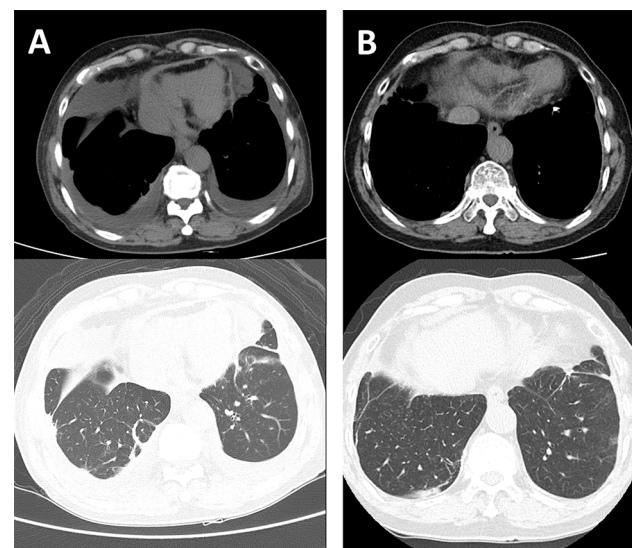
HRCT imaging. Chest computed tomography showed some calcified granuloma within the pleura in the left lower lobe, as well as bilateral pleural effusion with some linear consolidation and a small amount of pericardial effusion (A). Pleural effusion, pericardial effusion, and linear consolidation improved after surgery (B)
